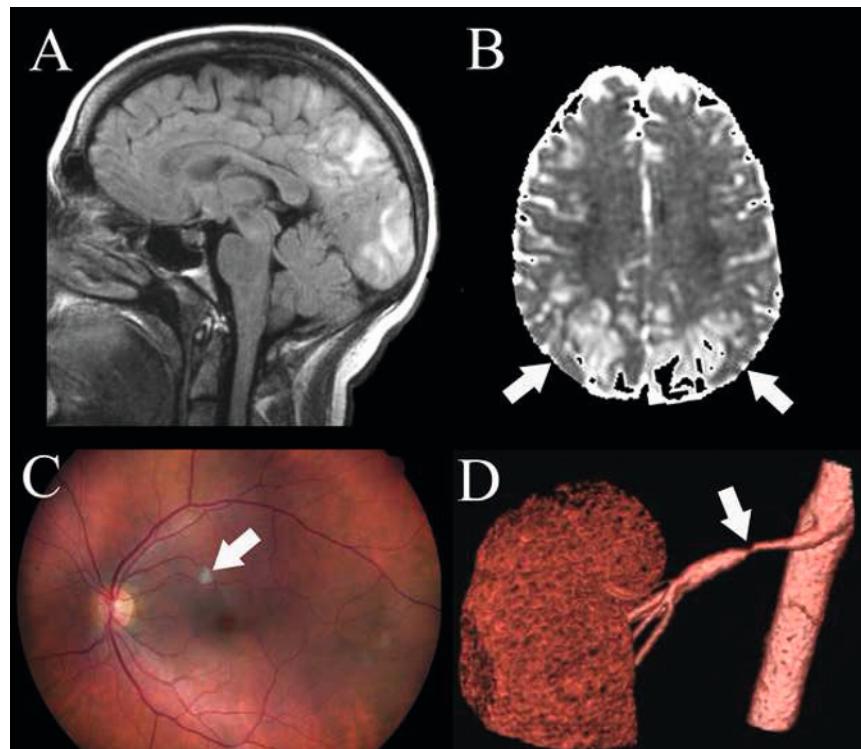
A. B. Brain MRI showing subcortical and cortical hyperintense signal predominant in posterior regions on FLAIR- (A) and ADC-weighted (B) imaging (vasogenic oedema). Arrows: ADC hyperintense lesion. C. Eye fundus examination showed hypertensive-related retinal exudates (indicated by arrow). D. CT angiography revealed high grade stenosis of the right renal artery (indicated by arrow), responsible for hypertension, with post-stenotic dilatation.
